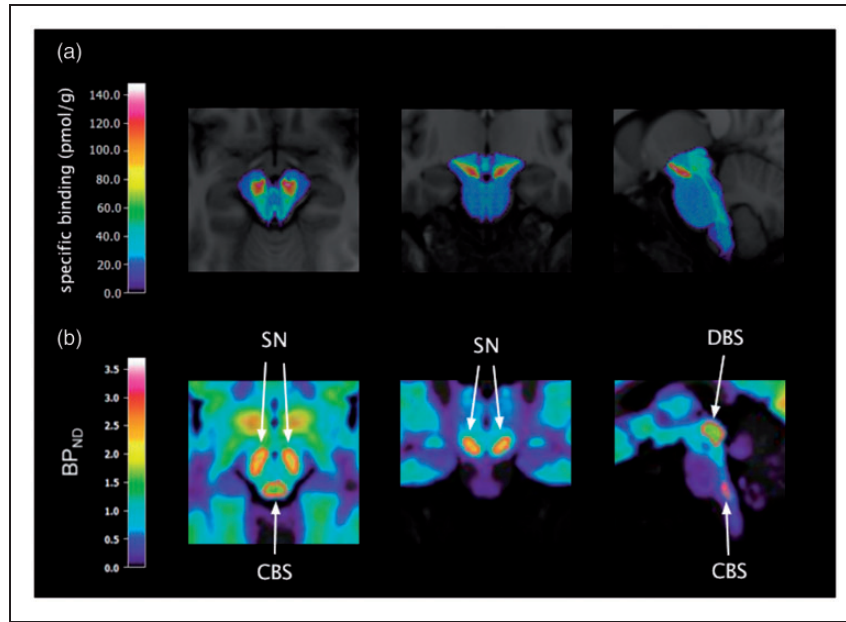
(a) [^3H]AZ10419369 ARG binding in the brainstem transformed to MNI space, overlaid on the template MR image; (b) template VOIs (in red) of the dorsal brainstem (DBS), substantia nigra (SN) and caudal brainstem (CBS) on the template [^{11}C] AZ10419369 PET image.
